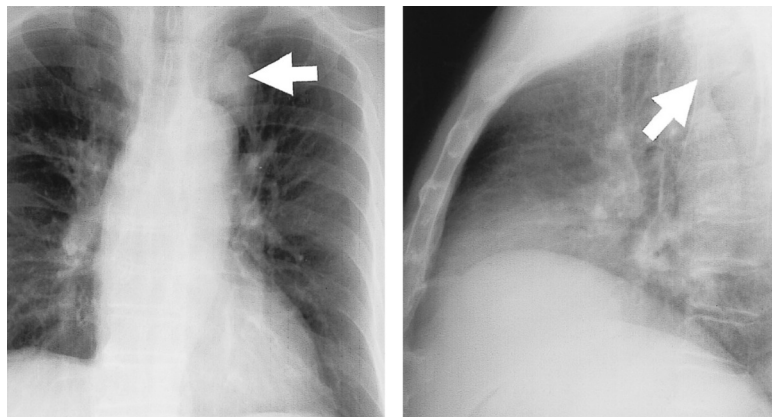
Chest x-ray film revealed a round shadow at the left upper posterior mediastinum.
